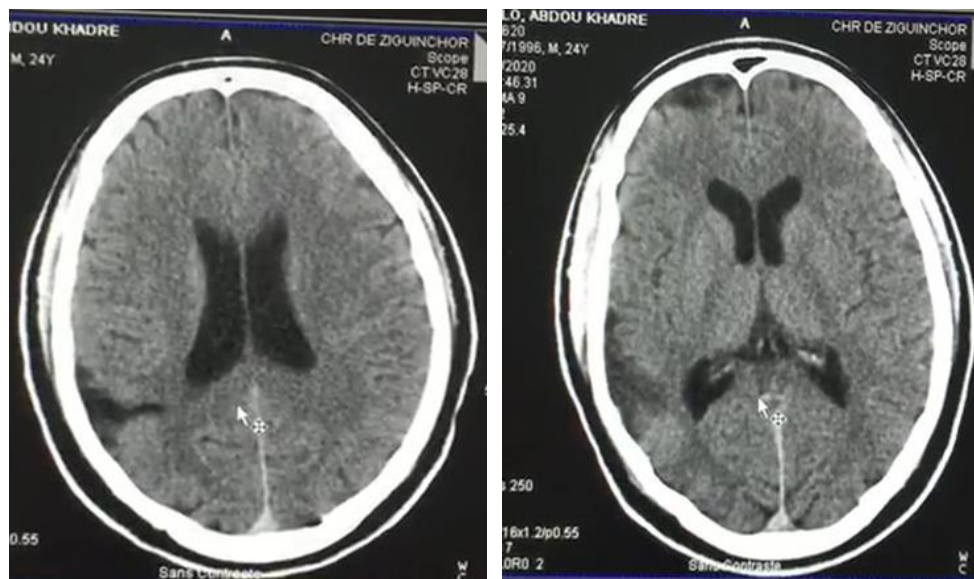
Follow-up Brain CT Scan at one month after trauma showing complete resorption of hemorrhagic lesions
